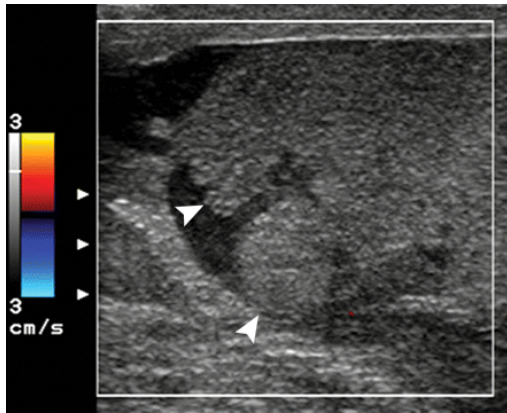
Testicular rupture. Longitudinal color Doppler US image of the right testis in a patient with more severe scrotal trauma shows complete disruption of the tunica albuginea with testicular contour abnormality (arrowheads) and no vascularity. The contralateral testis (not shown) also was ruptured. A bilateral orchiectomy was performed.
